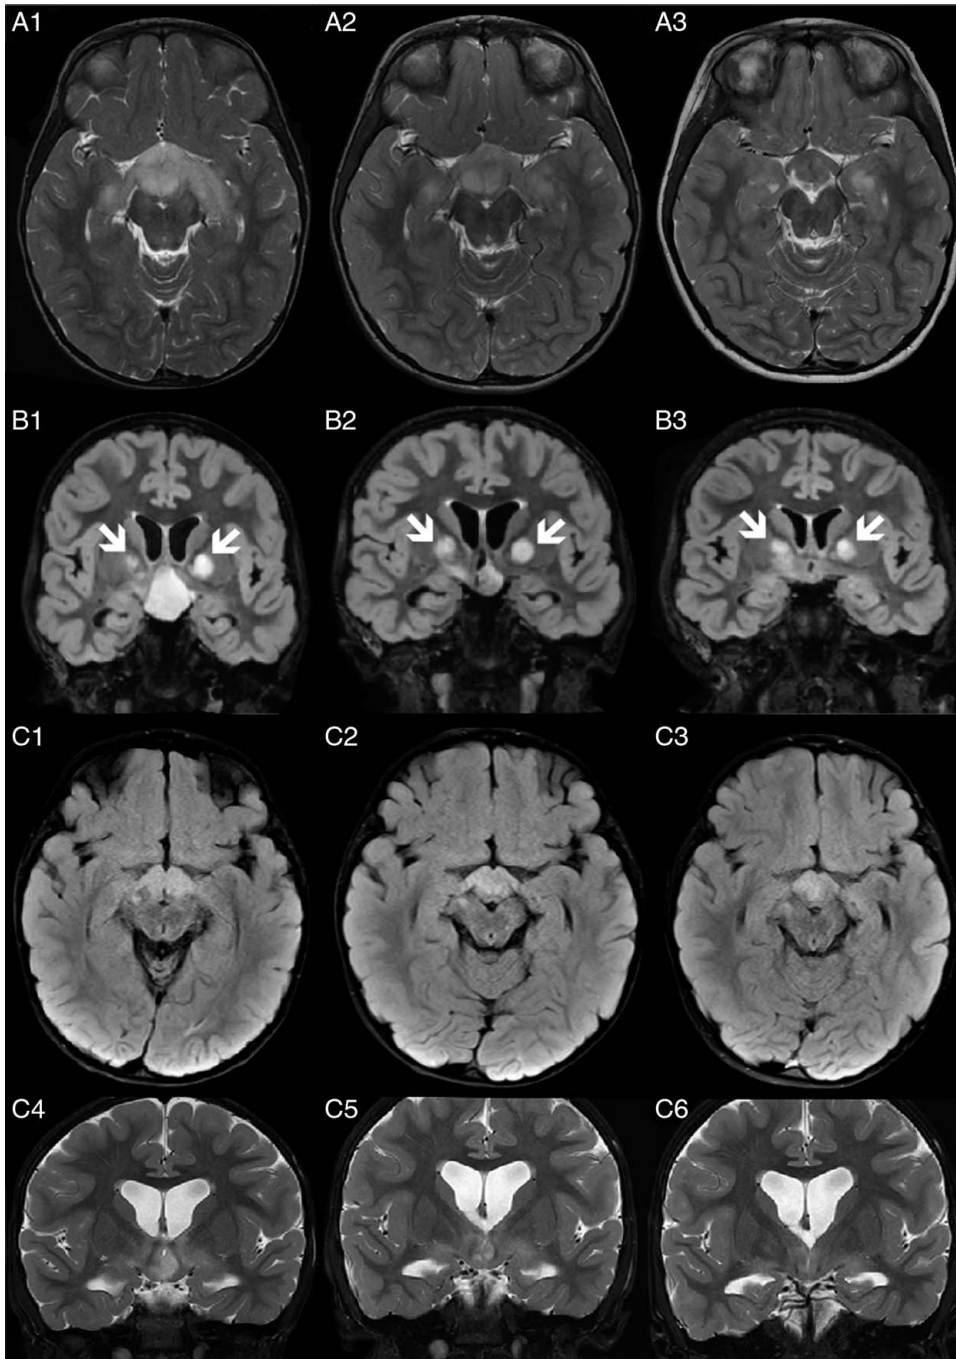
Representative magnetic resonance images at diagnosis, at first magnetic resonance imaging follow-up and end of treatment. Patient 1 at diagnosis (A1), 2.8 months after start of VBL and bevacizumab (A2) and at end of treatment (A3); axial T2. Patient 2 at diagnosis (B1), 3.1 months after start of VBL (B2), and at end of treatment (B3); coronal FLAIR. Focal signal hyperintensities specific for NF1 in bilateral globus pallidus (white arrows). Patient 3 at diagnosis (C1), 2.7 months after start of VBL (C2) and at end of treatment (C3); axial T2. Patient 3 at progression (C4), 2.5 months after start of trametinib (C5), and at last follow-up 13.8 months after start of trametinib (C6); coronal T2. FLAIR indicates fluid-attenuated inversion recovery; VBL, vinblastine.
